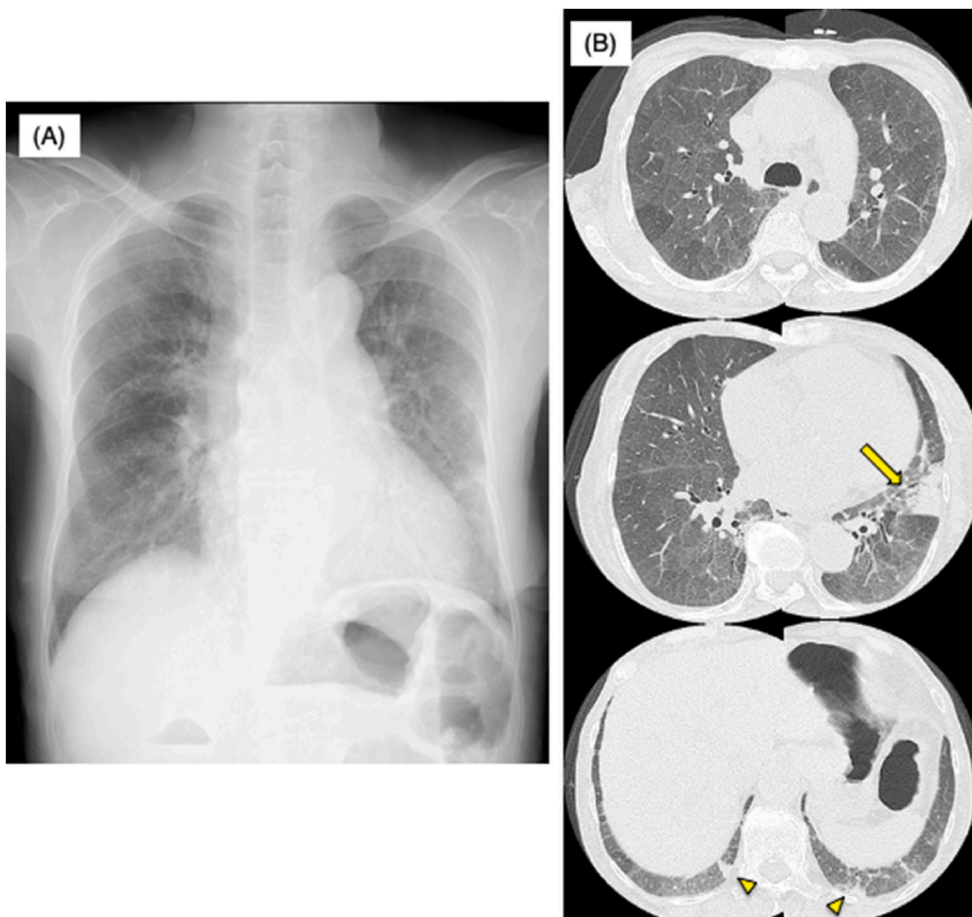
Radiological findings of the patient. (A) A chest X-ray image on admission. (B) Chest CT images on admission showing diffuse ground-glass opacities (GGO) with mosaic attenuation, consolidation in the left lingular lobe (arrow), and subpleural, wedge-shaped nodules in the bilateral lower lobes (arrowhead).
